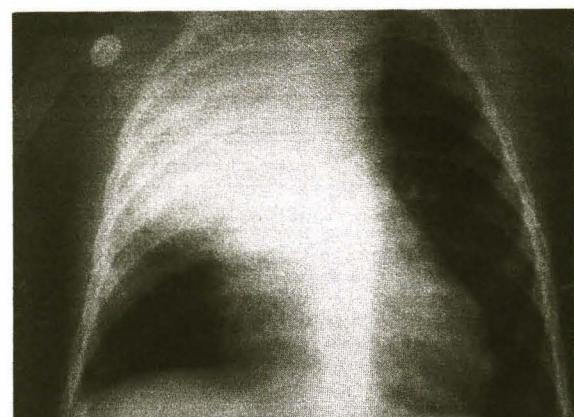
Chest radiograph demonstrates a haziness that occupies the entire right upper chest.
